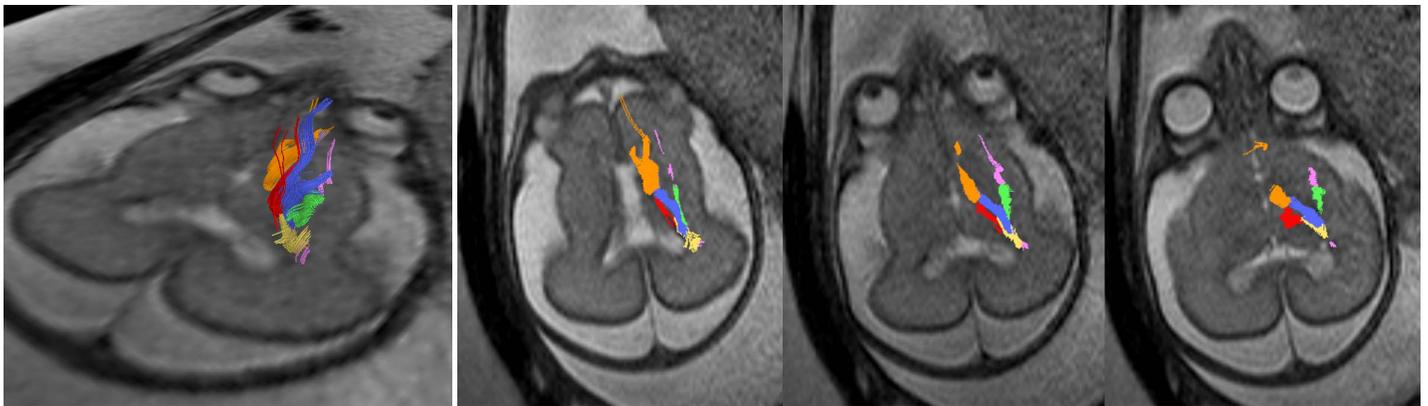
Left: 3-dimensional visualization of fetal periventricular crossroads at 27 GW. Anterior, superior and posterior thalamic radiation (orange, red and yellow respectively), corticopontine/corticospinal fibers (blue), external capsule fibers (green) and association fibers (pink) are arranged as sagittally oriented strata. Right: 2-dimensional axial tract projection series shows the topographic relations of periventricular crossroad subcomponents. Tractography results are displayed on a coregistered T2-weighted image.
